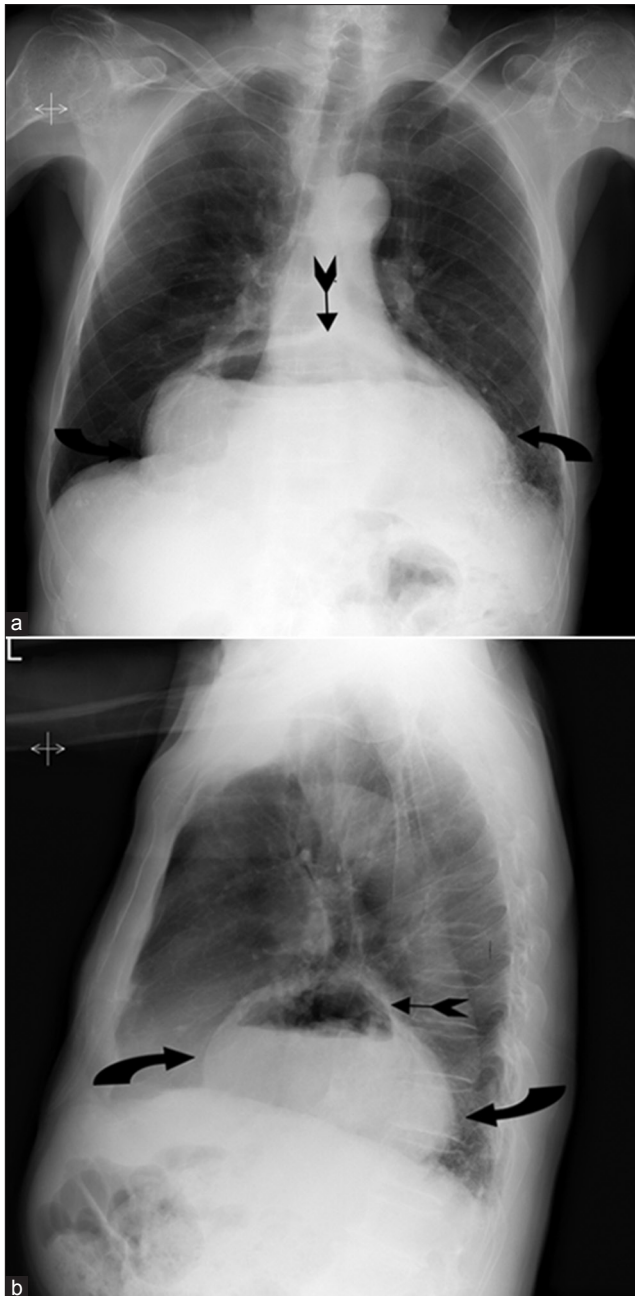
PA and lateral chest X-ray. (a) PA chest X-ray shows abnormal widening of the mediastinal contours (curved black arrows) with air-fluid level (straight black arrow) compatible with a large gastric hernia. (b) Lateral chest X-ray shows abnormal opacity in the middle mediastinum (curved black arrows) with air-fluid level (straight black arrow) consistent with a large gastric hernia
